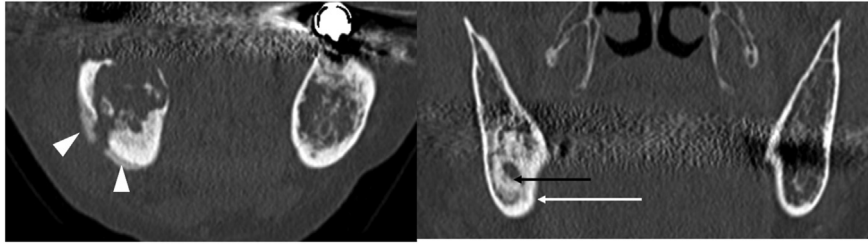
Preoperative CT findings. Left: Case 1: Extensive osteolytic lesion and PR (white arrow), and osteosclerosis in the right mandible. Right: Case 3: Thickening of cortical bone of mandibular (white arrow) and thickening of mandibular canal wall (black arrow).
